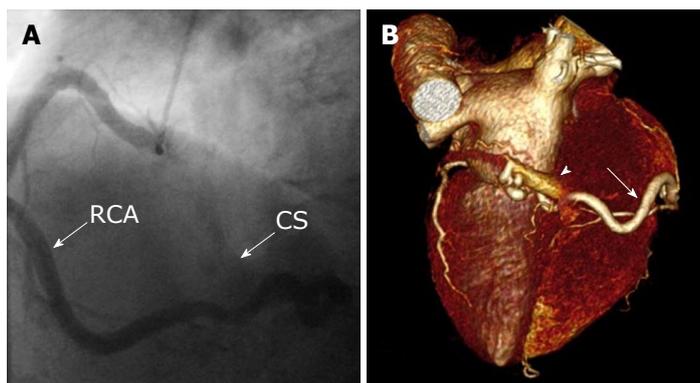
Unilateral fistula and computed tomography coronary angiography. A: Unilateral fistula originating from the right coronary artery (RCA) terminating into the coronary sinus (CS) with single origin, pathway and termination with dilated RCA and enlarged CS; B: Computed tomography coronary angiography: Coronary artery fistula originating from the distal segment of RCA (arrow) and terminating into the coronary sinus. Volume-rendered three-dimensional image reconstruction demonstrating fistulous vessel located posterior connected with the CS (arrowhead). RAC: Right coronary artery; CS: Coronary sinus.
